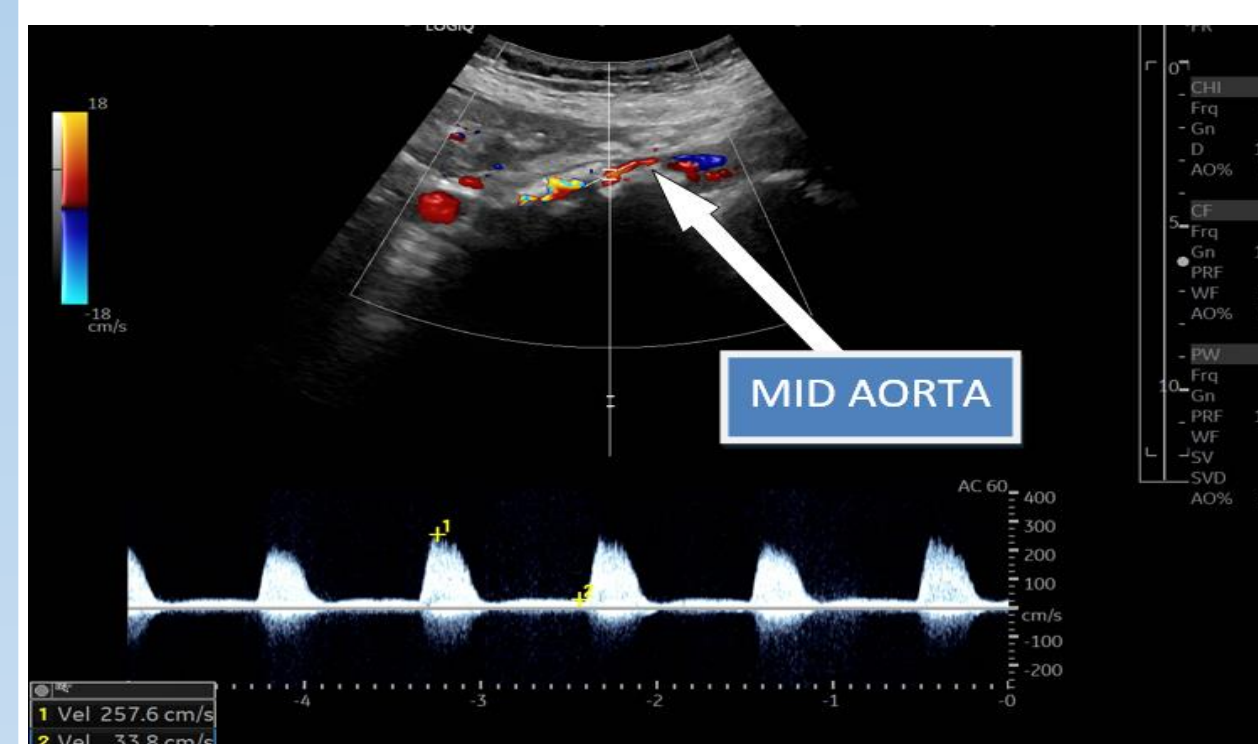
Spectral Doppler of the mid-abdominal aorta indicating a peak systolic velocity of 257 cm/s.
